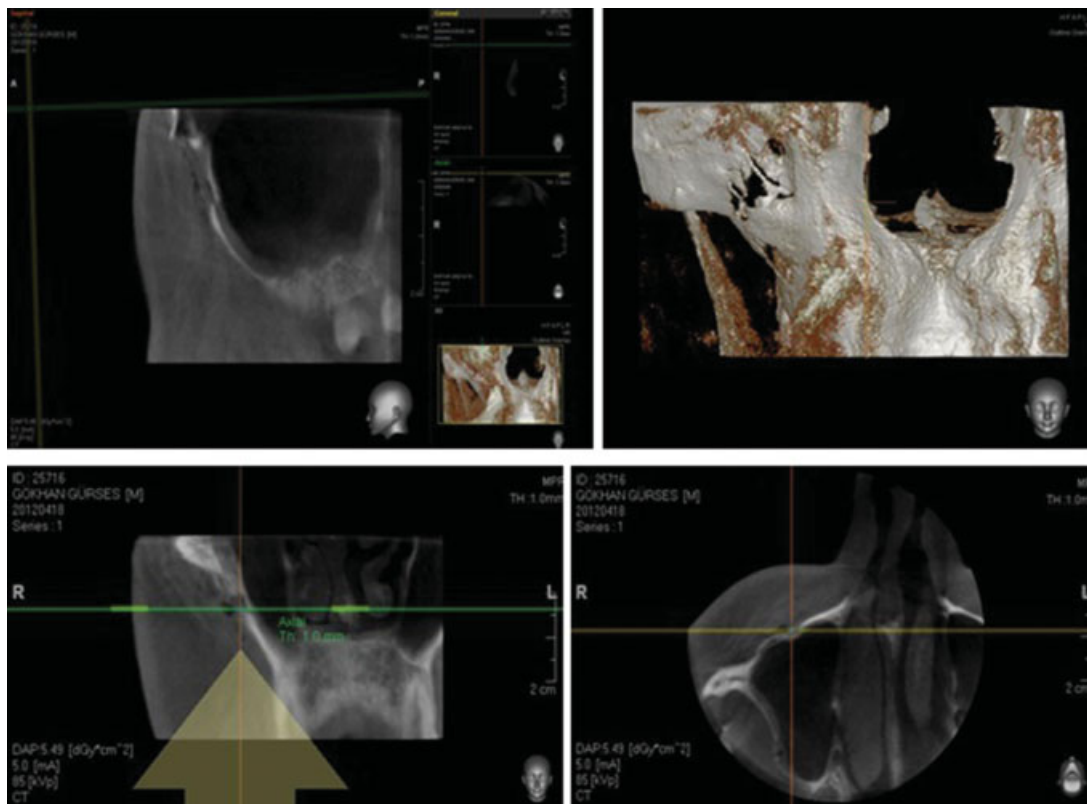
Cone-beam computed tomography images of the patient showing a nonfragmented fracture line in the anterior wall of the maxillary sinus.
